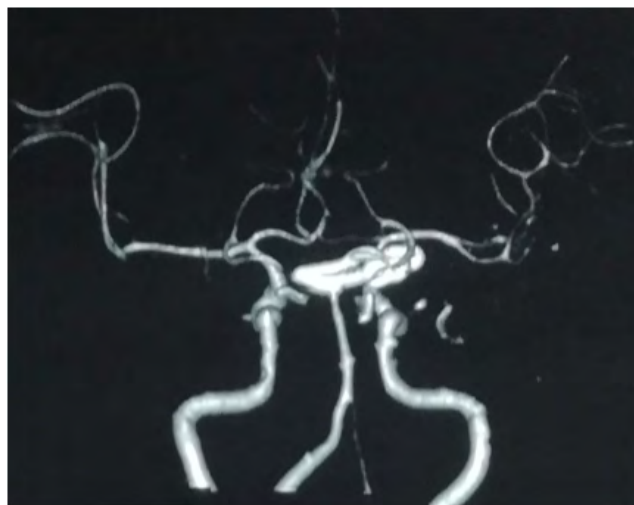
Postoperative CTA showed no existence of another aneurysm or vasospasm and the surgical clip was in the proper location.
